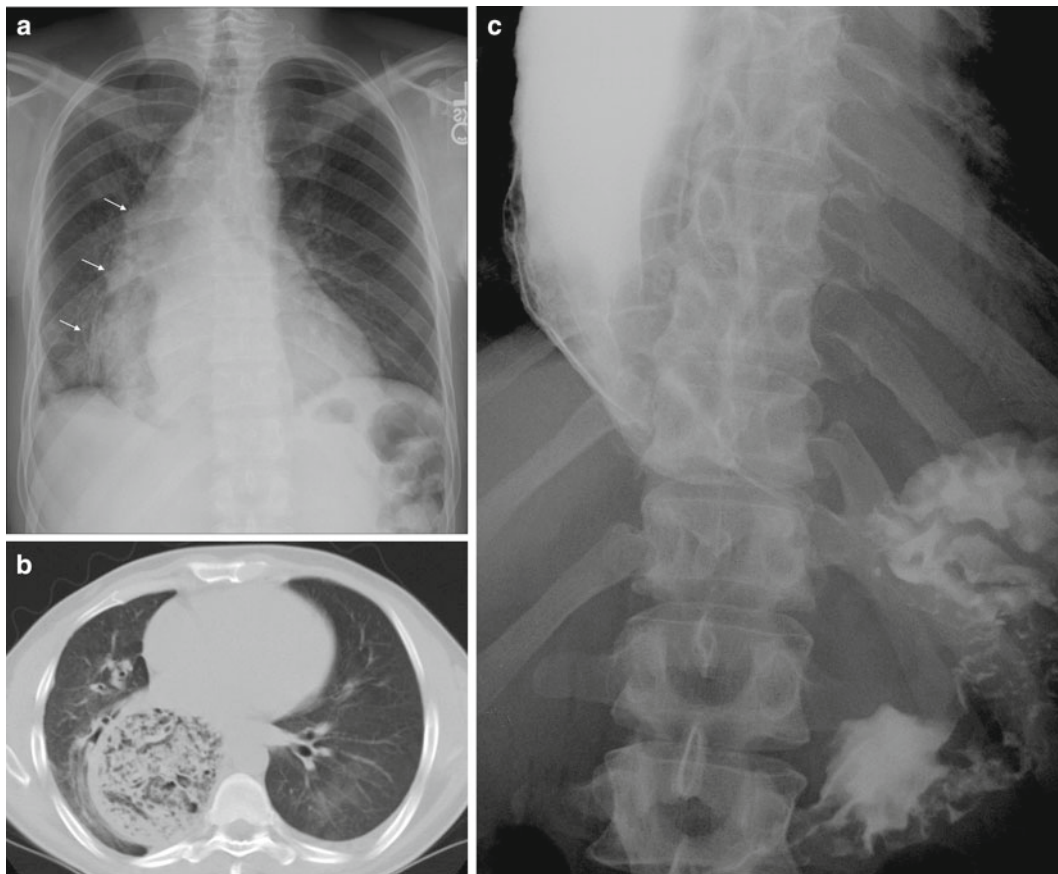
A 73-year-old woman is evaluated for progressive dysphagia, for solid foods and liquids. She has frequent episodes of regurgitation of undigested food and weight loss. Now she presents with acute chest pain. (a) PA chest X-ray shows a mass density along the entire right mediastinum (*white*
